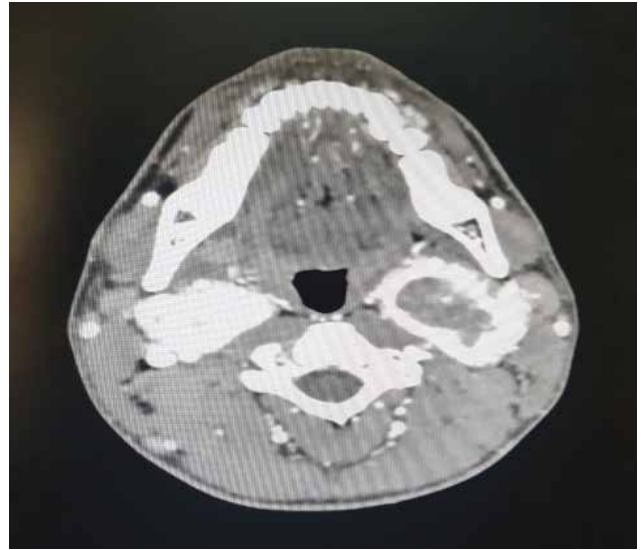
axial CE CT showing bilateral carotid body tumors showing avid enhancement with central necrotic area in left sided tumor
